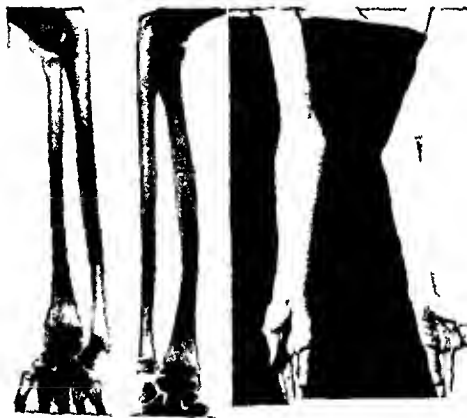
(Case XI) —Injury to upper end of radius at age of nine radial head removed at that time. Roentgenograms and photograph show the result four years later. There is a valgus deformity of the elbow with overgrowth of the lower end of the ulna producing a radial deviation of the hand and a prominence over the ulnar styloid.
